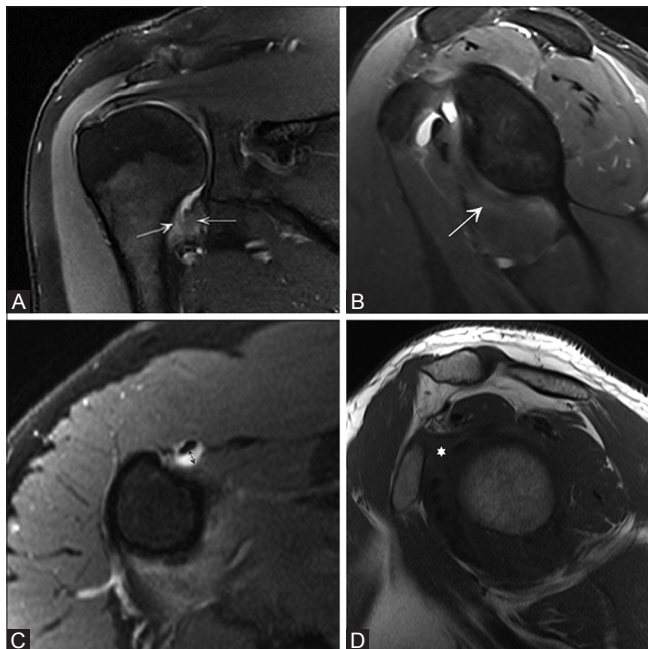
(A-D): (A) Coronal fat-suppressed proton density (PD) image at the level of axillary pouch shows edema of inferior glenohumeral ligament on both the humeral and glenoid aspects (arrows). (B) Sagittal fat-suppressed PD image shows anterior pericapsular edema (arrow). (C) Axial fat-suppressed PD image at the level of humeral neck shows fluid around the biceps tendon (arrow). (D) Sagittal T1-weighted image shows obliteration of fat in the subcoracoid triangle (asterisk)
